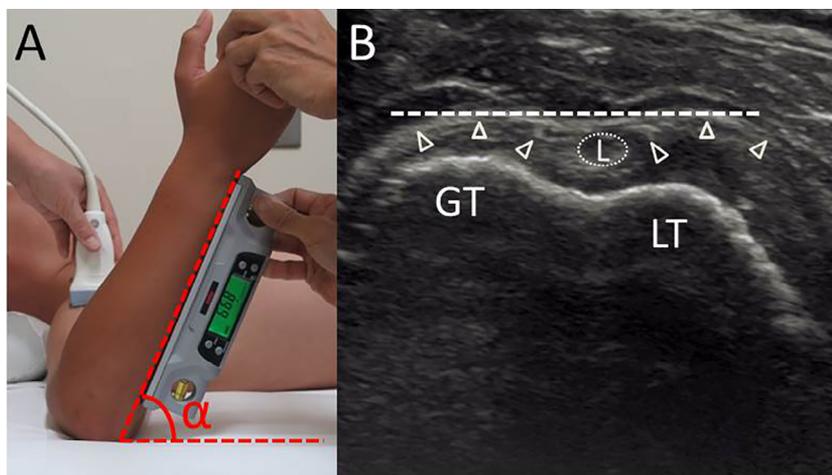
Humeral torsion angle (HTA) assessment. (A) Participants were positioned supine with 90° of shoulder abduction and 90° of elbow flexion. An ultrasound 11-MHz linear array transducer was placed on the participant's anterior shoulder perpendicular to the horizontal plane. A digital inclinometer was placed on the ulnar side of the forearm, and the angle between the participant's forearm and horizontal plane was measured (this angle α represents HTA). (B) Ultrasound image used for HTA measurement. The participant's humerus was passively rotated so that the bicipital groove appeared in the center of the ultrasound image with the line connecting the apices of the greater and lesser tubercles parallel to the horizontal plane. GT, greater tuberosity; LT, lesser tuberosity; L, long head of the biceps tendon. The white triangles (Δ) indicate the cartilage surface of the greater and lesser tubercles.
